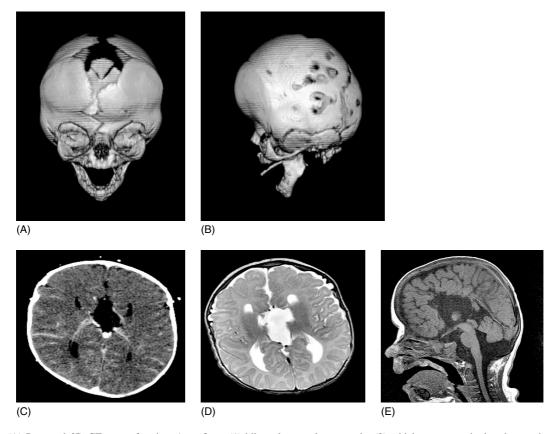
(A) Postnatal 3D CT scan of patient 1 confirms (1) bilateral coronal synostosis, (2) widely patent sagittal and metopic sutures, (B) (3) shallow orbits, (4) midfacial hypoplasia. (C) Axial CT with contrast, (D) axial FSE T2-weighted MRI and (E) sagittal T1 MRI image confirm agenesis of the *corpus callosum*
